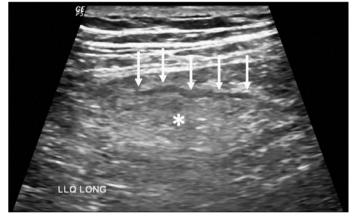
Longitudinal ultrasonographic image from left lower quadrant shows increased pericolic fat echogenicity (asterix) surrounded by a hypoechoic rim (arrows)
